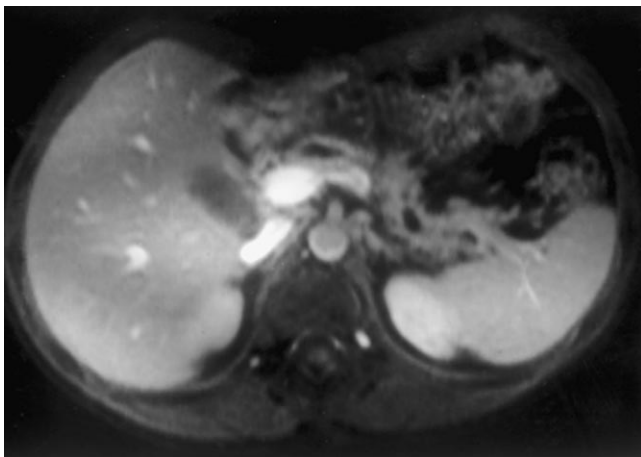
Chronic pancreatitis. Contrast enhanced MRI. Dilatation of the main pancreatic duct.
